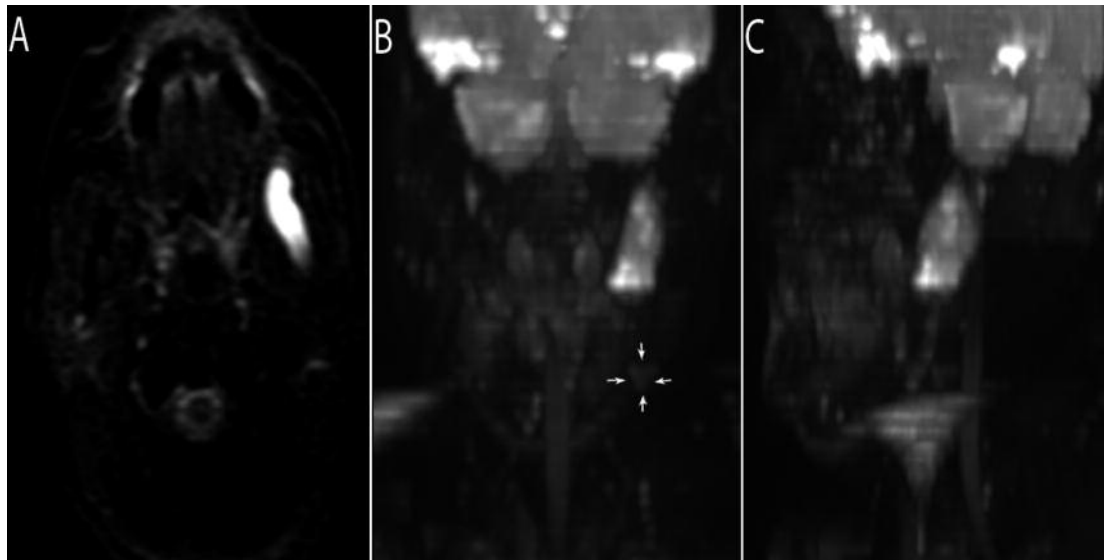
Diffusion weighted imaging acquisition (DWI $b = 800$): A, Axial diffusion-weighted MR image at $b = 800$ s/mm^2 shows an high signal intensity of the lesion. B-C, High resolution 3D Volume Rendering 3DVR-MRI shows enlarged nodes, ipsilateral to the lesion, in the upper part of the neck which exhibit low signal intensity. The white arrows indicate an enlarged node.
